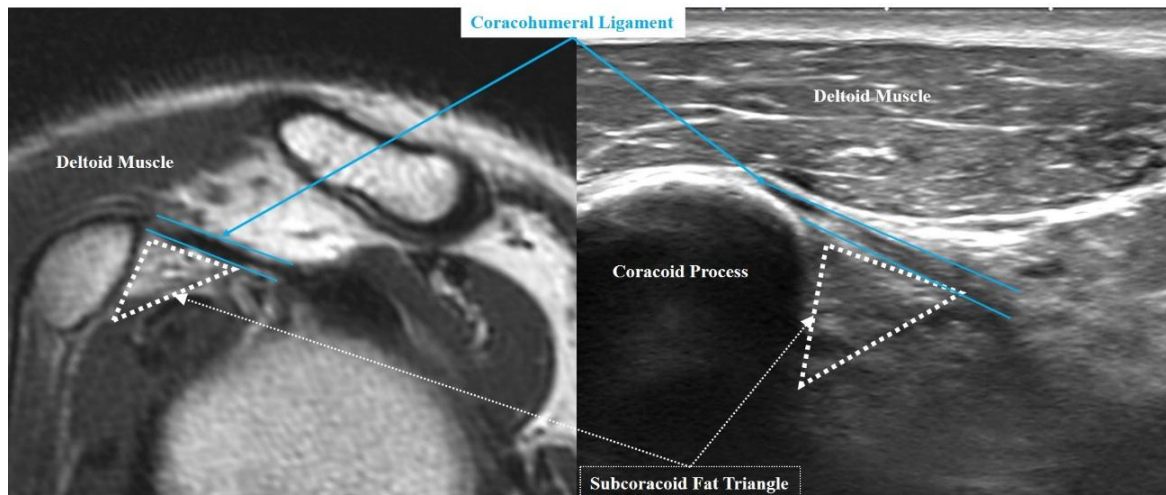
Anatomy and US examination of the subcoracoid fat triangle. Oblique sagittal MRI (left column) and US images (right column) of subcoracoid fat triangle (dotted triangle). Subcoracoid fat triangle is the triangular space between the coracohumeral ligament and the coracoid process, showing high echogenicity
